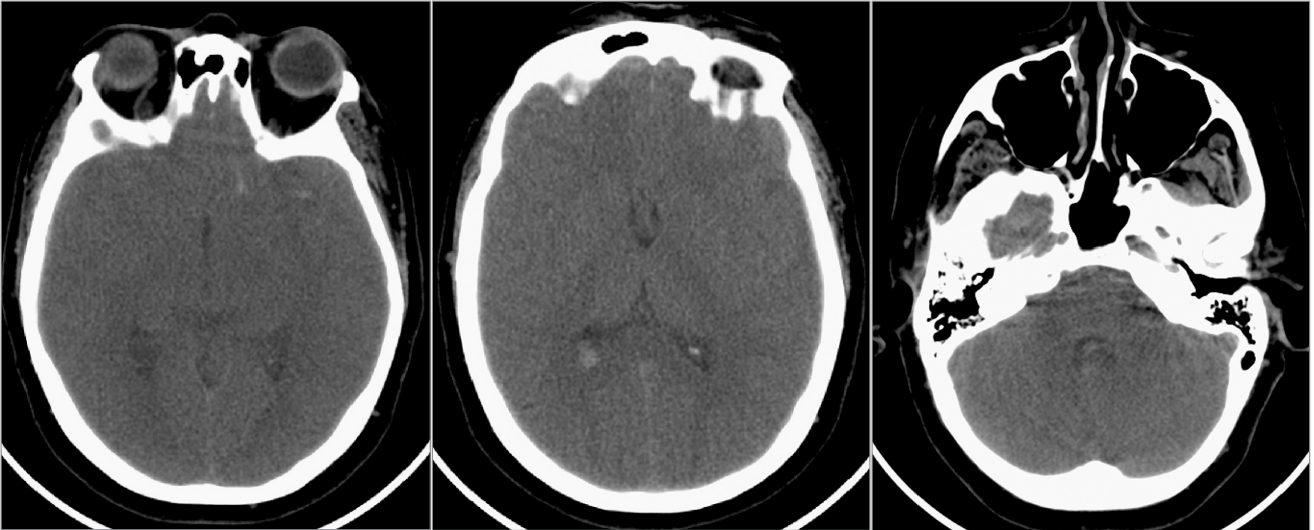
Computed tomography of patient N. on the first admission to the hospital
